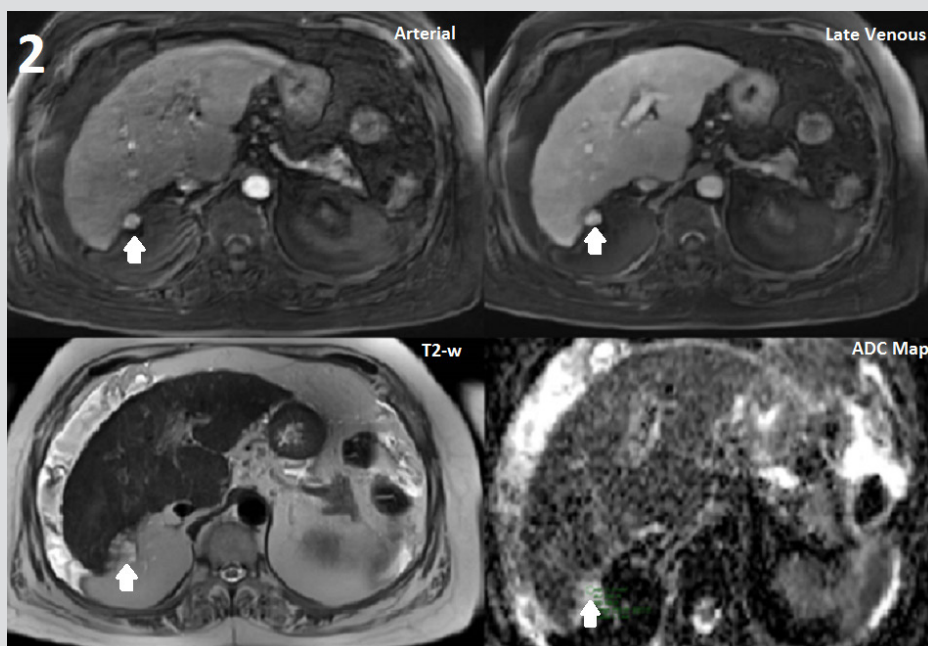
Contrast-enhanced (gadoxetate) MRI scan images (arterial phase, late venous phase, T2-w and ADC map), showing the exophytic lesion (white arrows)
